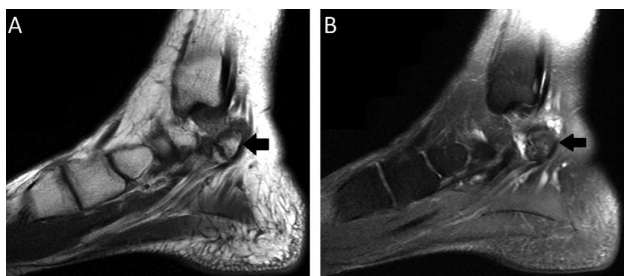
MRI of the right ankle in the sagittal section at T1 sequence in A and T2 FAT SAT sequence in B showing a talocalcaneal coalition with *Os sustentaculum* (black arrows).
